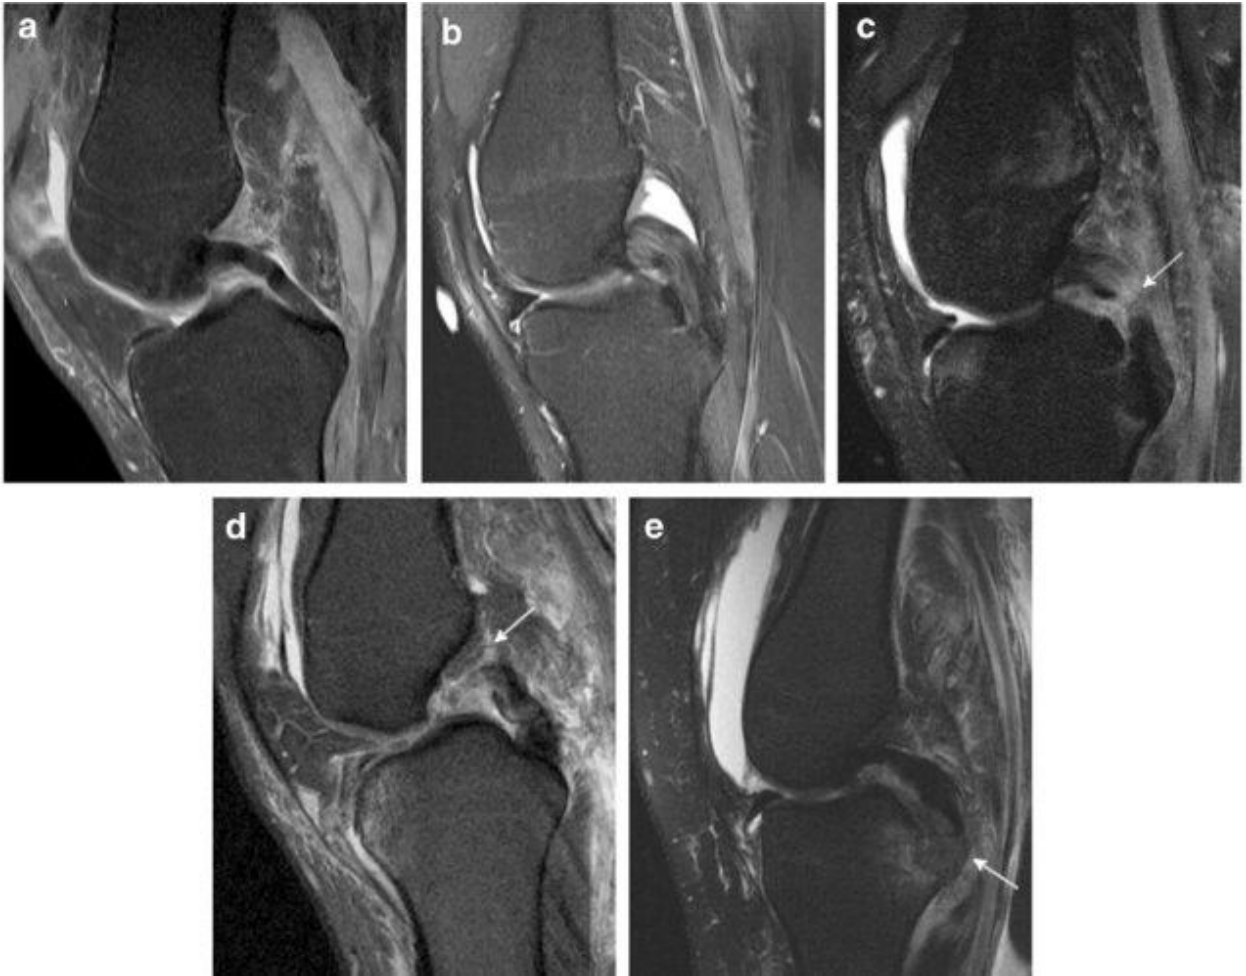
MRI scans of the PCL¹⁷
